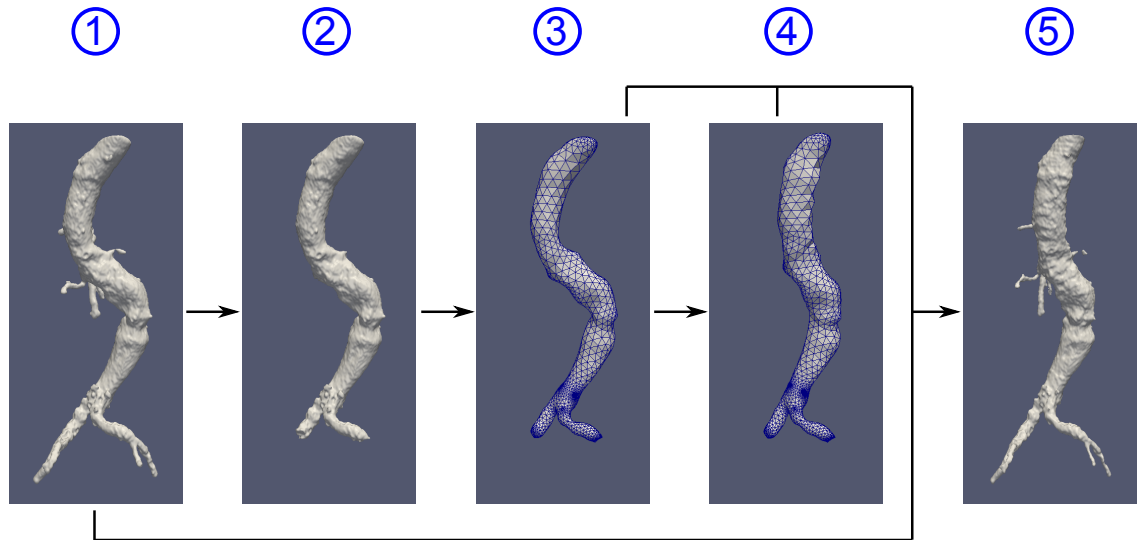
1) The pre-operative aorta is segmented from the CT volume. 2) The pre-operative segmentation is ‘cleaned-up’: branches are removed and the top and bottom parts are cropped. 3) The pre-operative aorta is meshed. 4) The pre-operative aorta mesh is deformed using finite-element methods. 5) A displacement field is computed using node correspondences from the pre-operative aorta mesh (source nodes) to the deformed mesh (target nodes). The calculated displacement field is applied to the pre-operative aorta. An ‘intra-operative’ aorta is computed using a thin-plate spline deformation with the source and target points mentioned previously.
